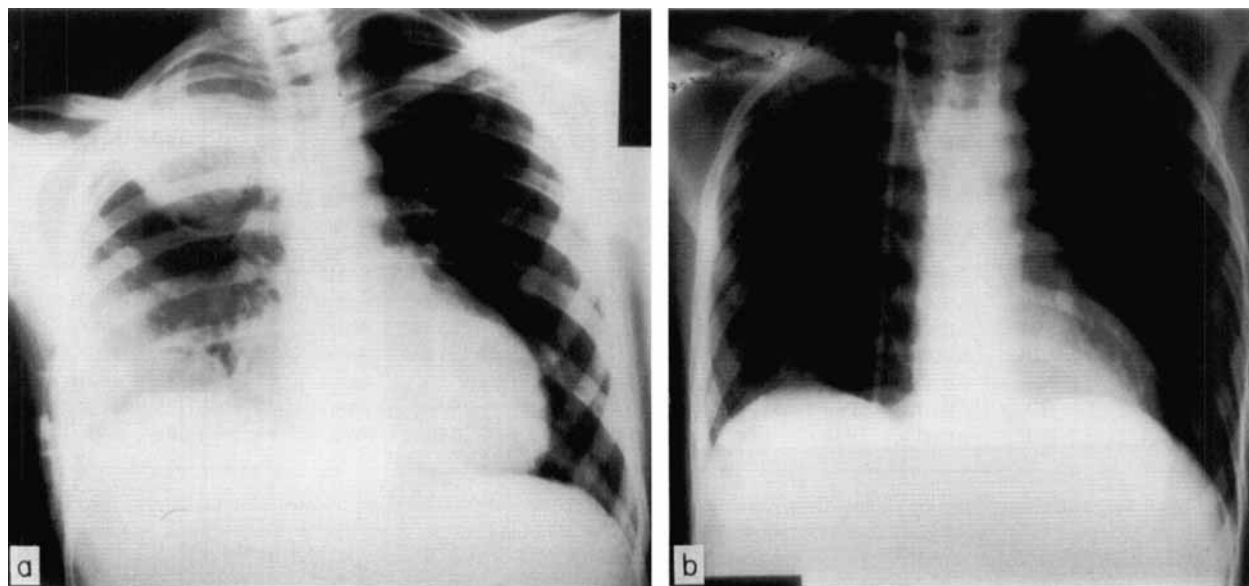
(a) Radiographic appearance typical of patients with suspected aspergillosis; (b) the response after treatment with liposomal amphotericin.
